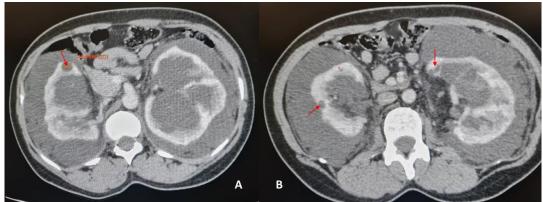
(A and B): Abdominal CT with axial reconstruction with MIP passing through both kidneys showing small cortical cysts (red arrow)
